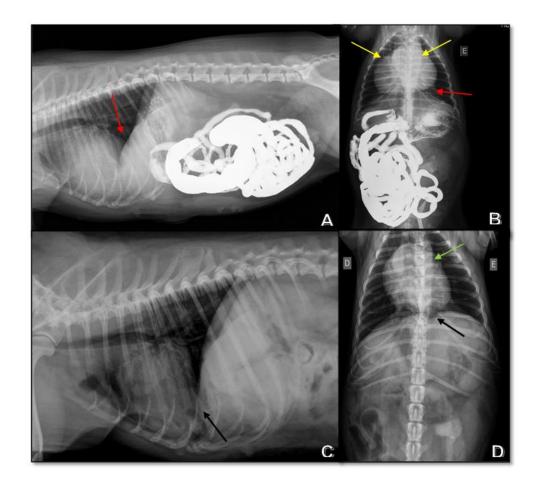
Pre- and postoperative simple and contrast radiography 187 images in latero-lateral (A), ventral-dorsal (B), latero-lateral (C), and 188 ventral-dorsal (D) positions. (A) Contrast radiography image after oral 189 administration of barium showing loss of definition between the 190 diaphragmatic dome and the heart (red arrow), and absence of stomach and 191 intestines in the pericardial sac. (B) Contrast radiography image showing 192 increased cardiac silhouette and the presence of parenchymal organ in the 193 pericardial sac displacing the heart (yellow arrows). (C) Simple 194 postoperative radiography of peritoneopericardial herniorrhaphy with 195 196 definite limitation between the diaphragmatic dome and cardiac silhouette (black arrow). (D) Postoperative radiography image of peritoneopericardial 197 herniorrhaphy with restoration of the cardiac silhouette (green arrow) and 198 well-defined limitation between the thoracic and abdominal cavities (black 199 200 arrow).
